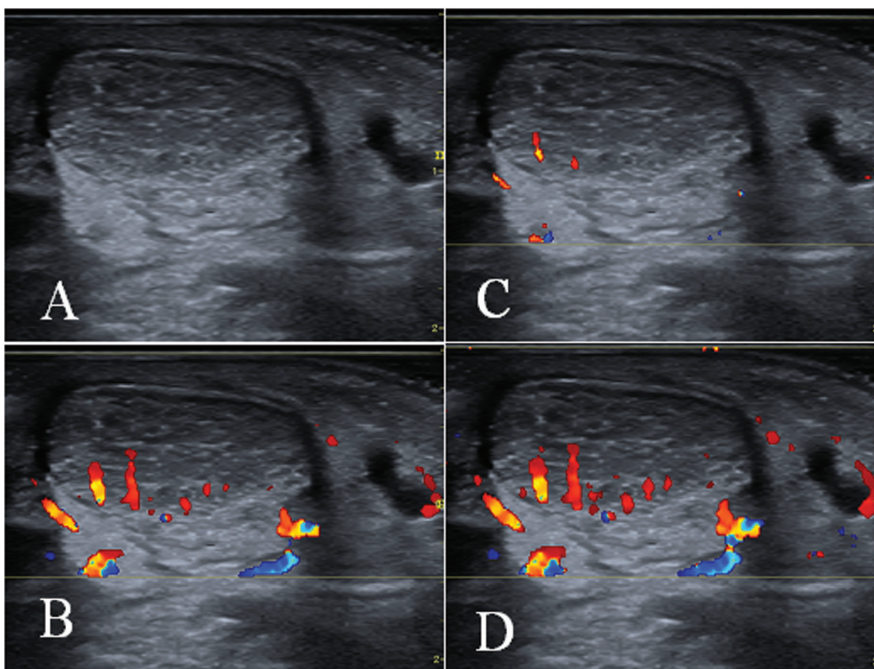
Blooming artefact in a patient with Achilles tendinosis. Transverse image of the Achilles tendon with medial oriented right showing intratendinous Doppler activity in different gain settings. A is the corresponding grey scale image and B is the Doppler image with the standard settings we use, allowing blooming as a systemic error. The blooming artefact displays colour outside the vessel making the vessels appear larger than they are because the artefact exceeds the vessel wall. Focussing on the two vessels outside the tendon (white arrows) the blooming inside these vessels can be adjusted by lowering the Doppler gain setting. However, by lowering the gain thereby minimizing the blooming artefacts the weakest signals are lost and the smallest vessels disappear in other part of the image (tendon). The change is clinically relevant because the evaluation changes from moderately hyperaemic (B) to slightly hyperaemic (C). Blooming can be enhanced by increasing the gain (D).
